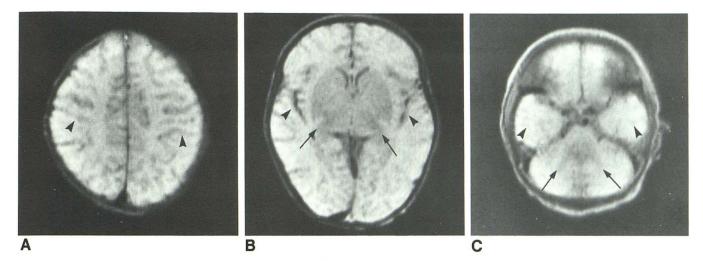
Infantile pattern in 6-day-old boy. Axial MR images (SE 2000/84). Supratentorial white matter has diffusely higher signal intensity than gray matter (arrowheads) at all levels. A, Level of centrum ovale.
